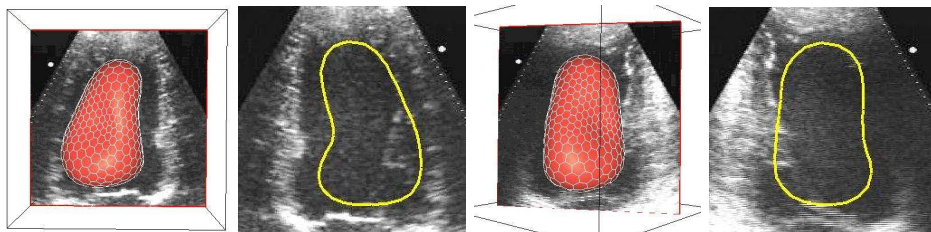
Model initialization inside the ultrasound image sequence. Left: surface model superimposed in the first sequence image and intersection with an image slice. Right: surface model superimposed to another slice and intersection with this slice.
